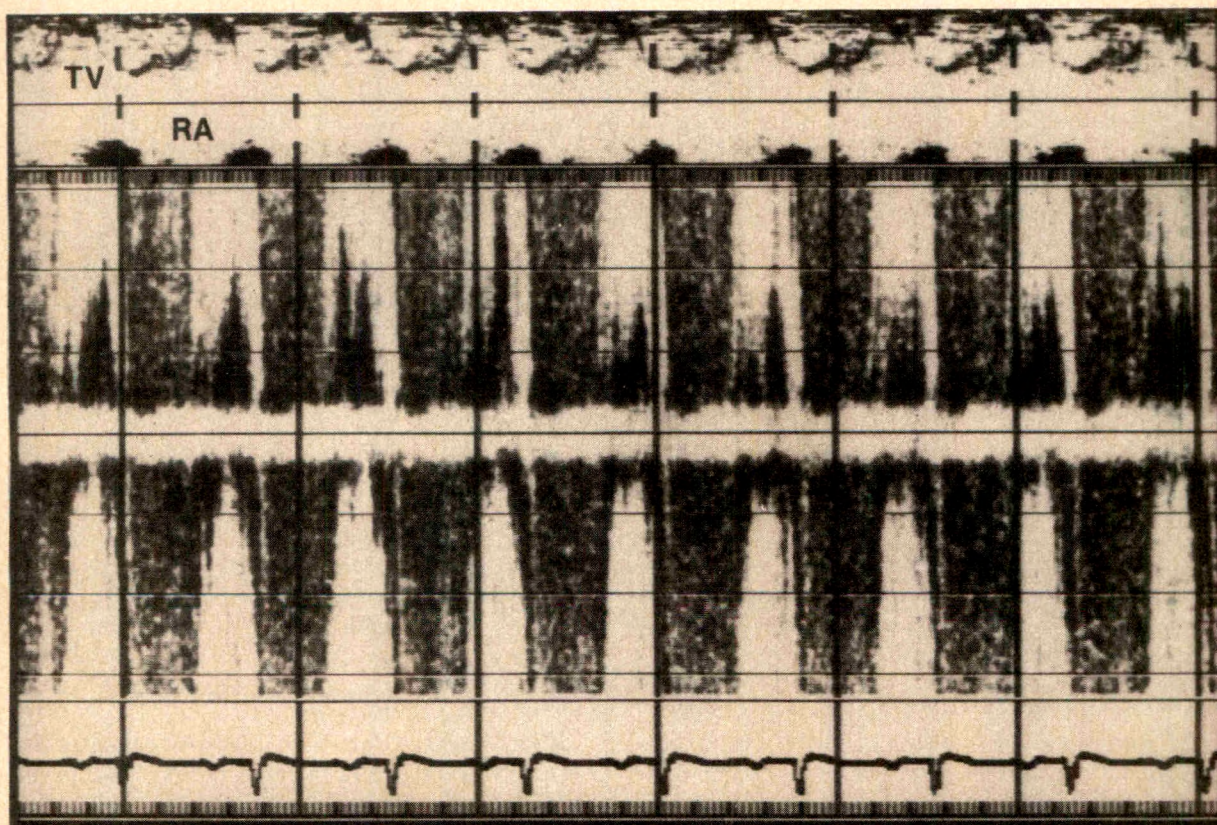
Moderate-to-severe tricuspid regurgitation by pulsed Doppler echocardiography. M-mode through the right ventricle, tricuspid valve (TV) and right atrium (RA) are shown at the top. Spectral velocity display in the pulsed mode demonstrates diastolic velocities going toward the transducer (upward), and marked systolic turbulence during systole with high velocities resulting in aliasing of the tricuspid regurgitation signal above and below the zero velocity line.
